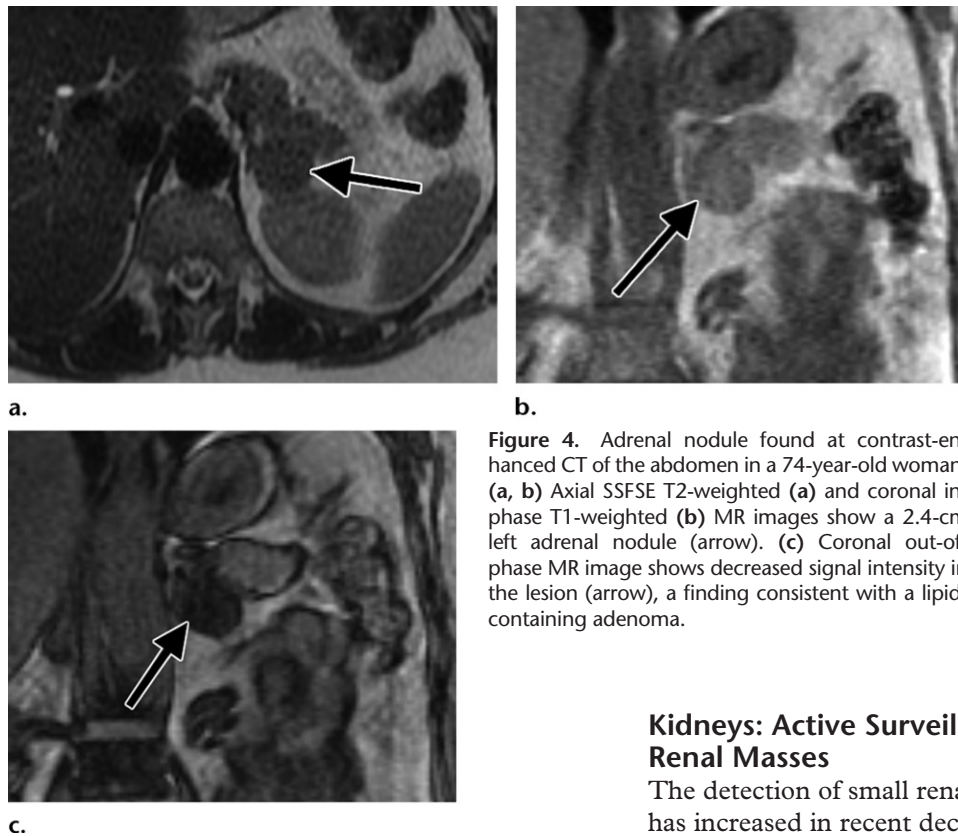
Adrenal nodule found at contrast-enhanced CT of the abdomen in a 74-year-old woman. (a, b) Axial SSFSE T2-weighted (a) and coronal in-phase T1-weighted (b) MR images show a 2.4-cm left adrenal nodule (arrow). (c) Coronal out-of-phase MR image shows decreased signal intensity in the lesion (arrow), a finding consistent with a lipid-containing adenoma.
